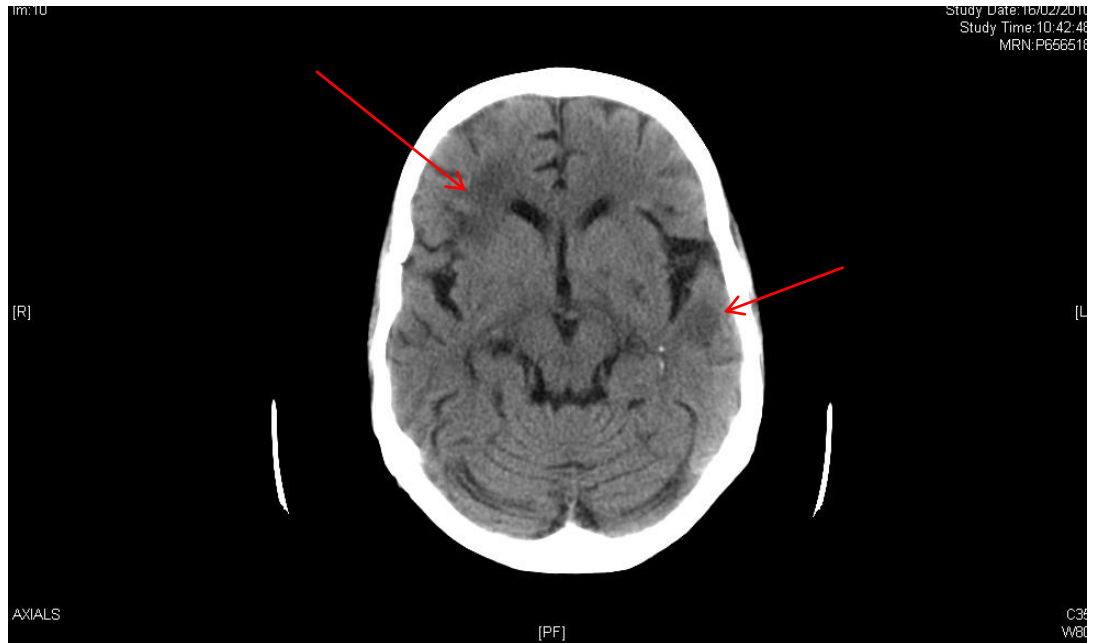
CT brain showing bilateral low density lesions in the right frontal lobe, predominantly involving white matter but extending to the insular, and anteriorly in the left temporal lobe, extending to the temporal operculum, the grey-white matter interface in the posterior right parietal lobe. No haemorrhage was identified. Unfortunately contrast could not be given due to the patient's poor renal function.
